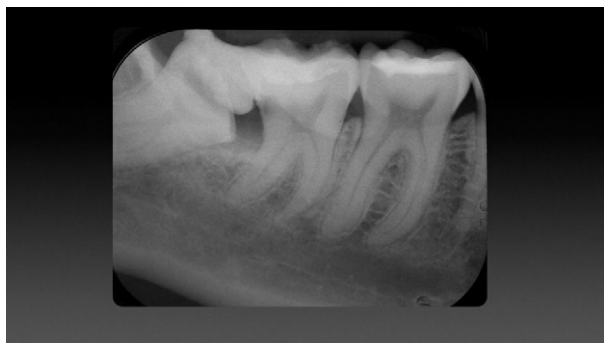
Postoperative radiograph after odontectomy. A space distal to the second molar is created to allow migration of the impacted tooth.
